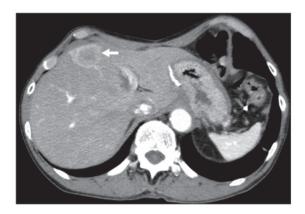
Abdominal computed tomography scan showing a 4.8-cm mass in the liver, which demonstrated strong enhancement following intravenous administration of contrast material (arrow).
